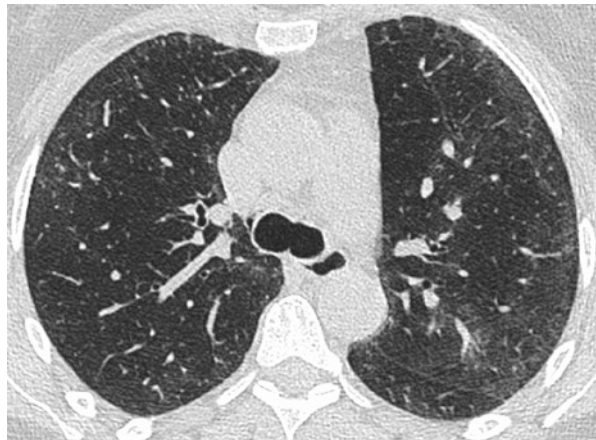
Axial HRCT image of the lower lobes in a patient with rheumatoid arthritis-related non-specific interstitial pneumonia (NSIP). In this patient, diffuse but predominantly subpleural textured ground-glass opacification is demonstrated containing areas of traction bronchiectasis particularly in the left lower lobe. Although honeycombing is absent, there is significant volume loss in the right lower lobe highlighted by the retraction of the right oblique fissure. A thin region of subpleural sparing is seen in the right lung at this level
